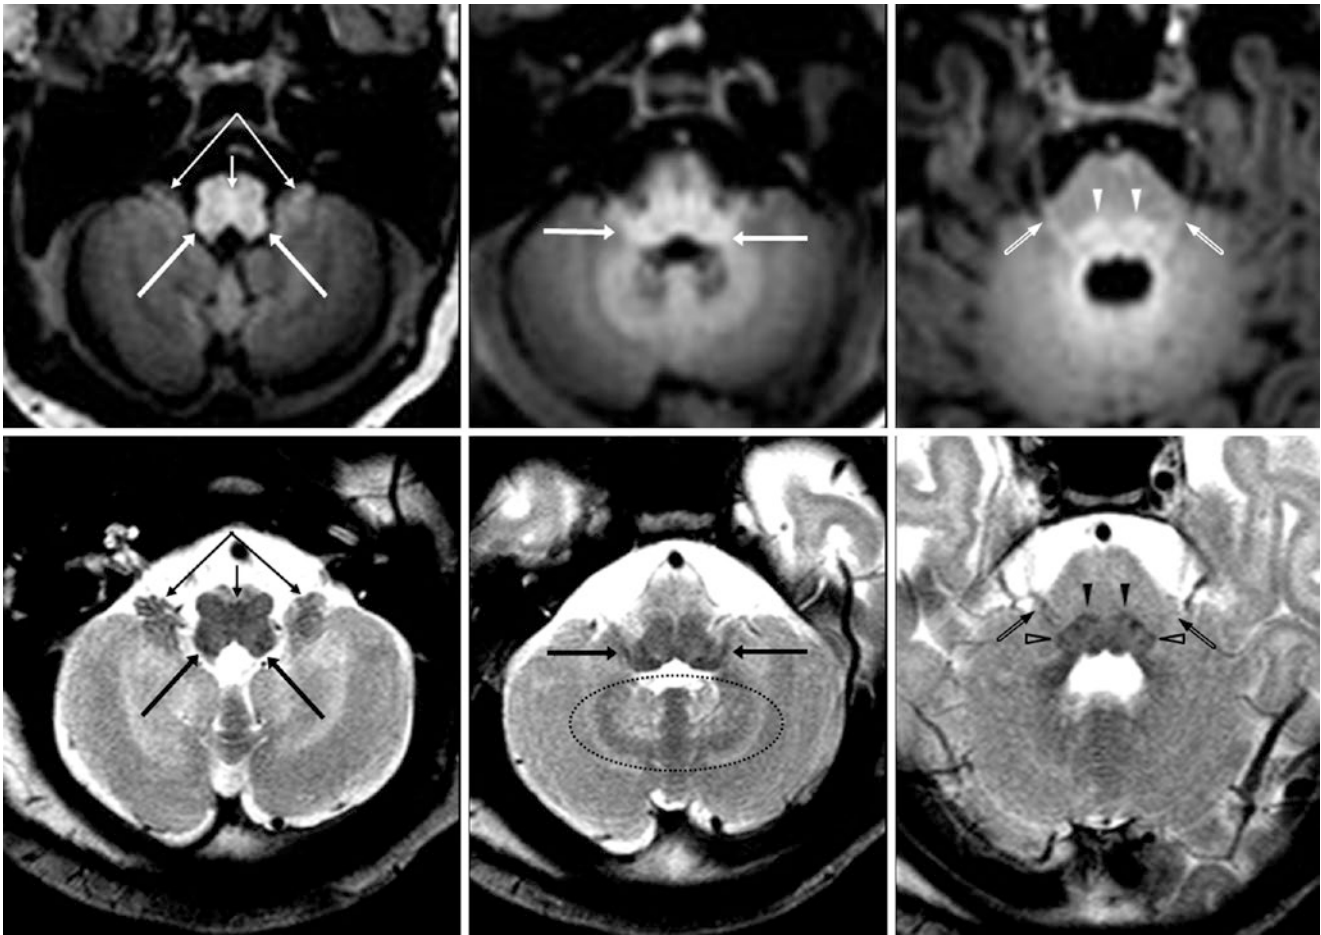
A 3-day-old term neonate had a normal 3T MRI with GE T1WI (top row) and SE T2WI (bottom row). Note the CNV (beveled arrows), ICP (long arrows), LL (open arrowheads), ML (arrowheads), and PD (tiny arrows). On SE T2WI, myelination of the cerebellar flocculi (split arrows) as well as of the nodulus and corpus medullare (dotted oval) are better visualized, while CNV and PD are better visualized on GE T1WI
